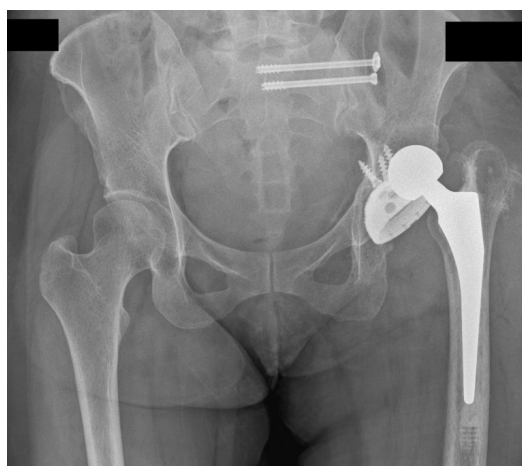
Early postoperative radiograph for left hybrid total hip arthroplasty
